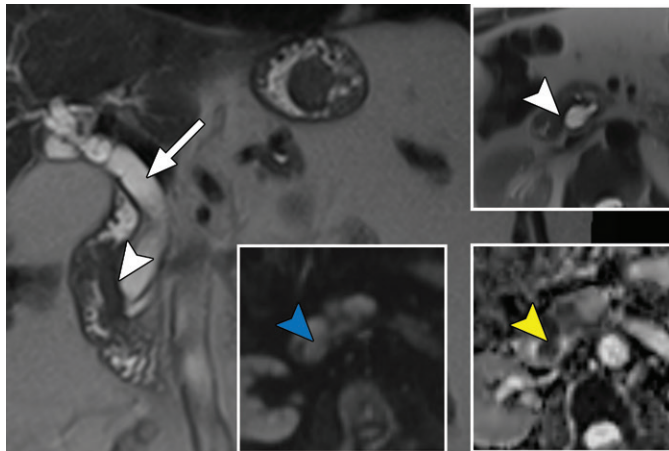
Overlooked ampullary mass in a 69-year-old woman with jaundice. Coronal T2-weighted MR image shows biliary ductal dilatation (arrow). The ampullary mass (white arrowheads) was not identified prospectively, with similar signal intensity to the normal duodenal wall on the coronal and axial (top right inset) T2-weighted MR images. Diffusion-weighted image (bottom left inset) and ADC map (bottom right inset) show diffusion restriction (blue arrowhead) and ADC hypointensity (yellow arrowhead), valuable clues for diagnosis that were identified at imaging review before endoscopic biopsy, the results of which confirmed ampullary adenocarcinoma.
